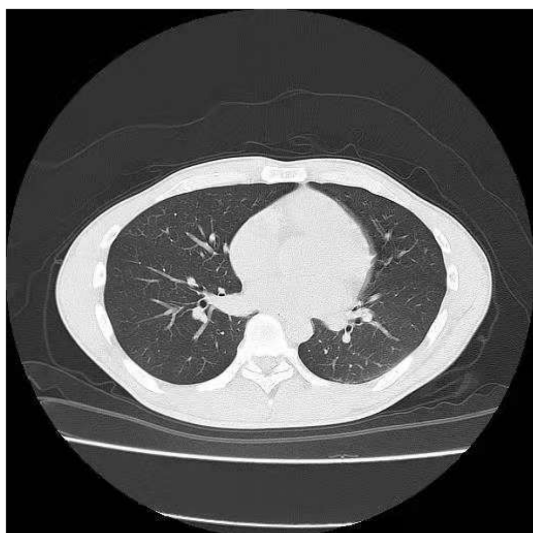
Twenty-four hours after admission, lung computed tomography showed increased lung markings.
